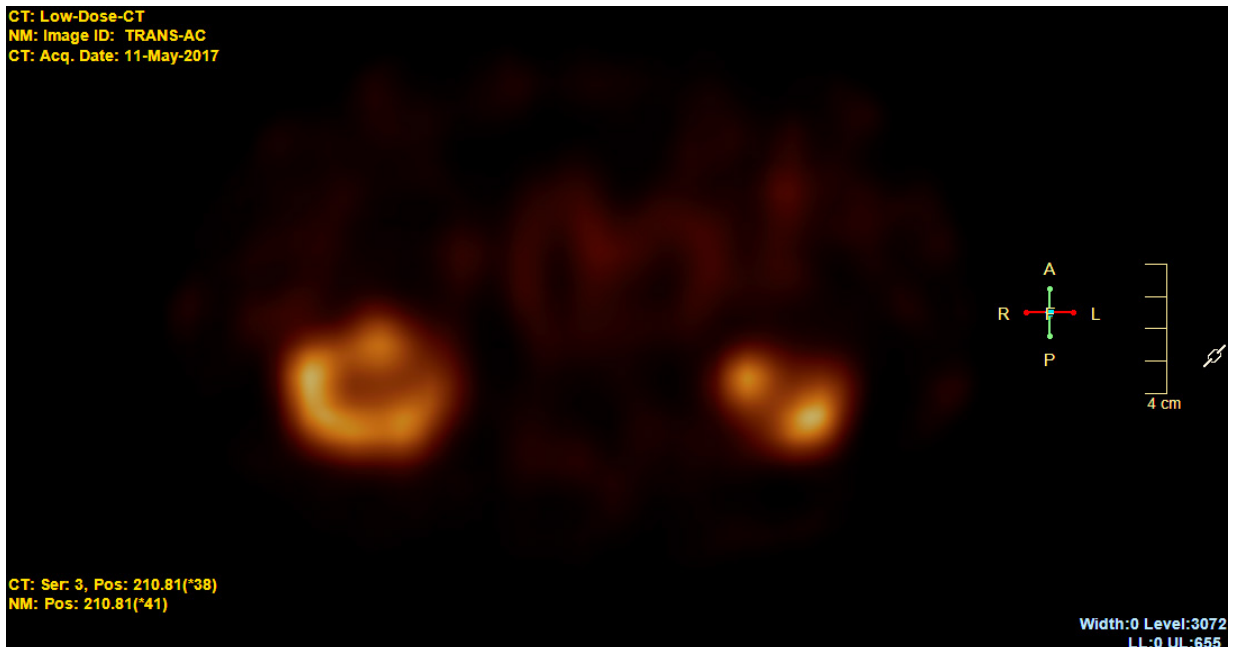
SPECT image with CTAC.
